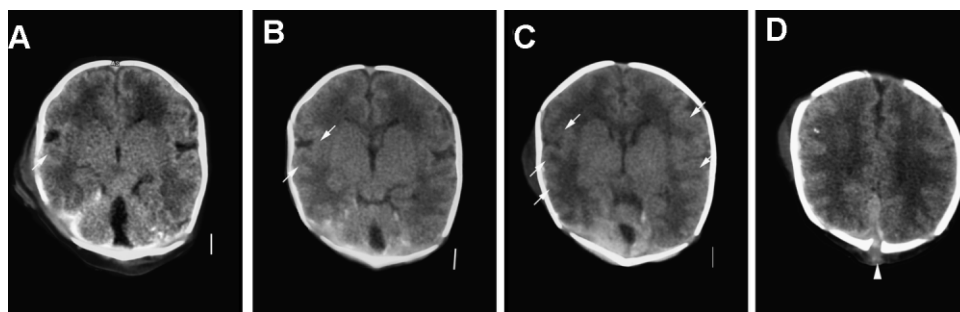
Brain CT images from a girl with deletion 1q44 (A–D, LP94-079) show an open sylvian fissure, reduced sulcation and mildly thick cortex (white arrows in each image) that suggest a cortical malformation. The lowest image demonstrates severe CVH based on lack of any vermis at the level of the midbrain (A), and the highest image shows a small occipital cephalocele (arrowhead in D). Images (A,B,D) are re-printed from Boland et al. [2007].
